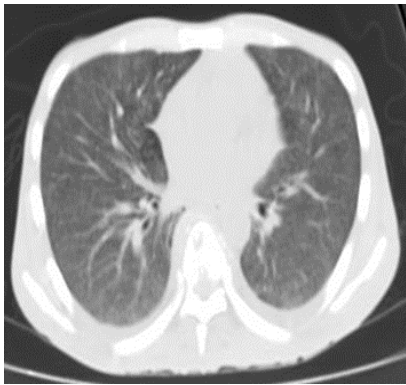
Axial CT lung window: Diffuse ground glass haziness with miliary nodules.
